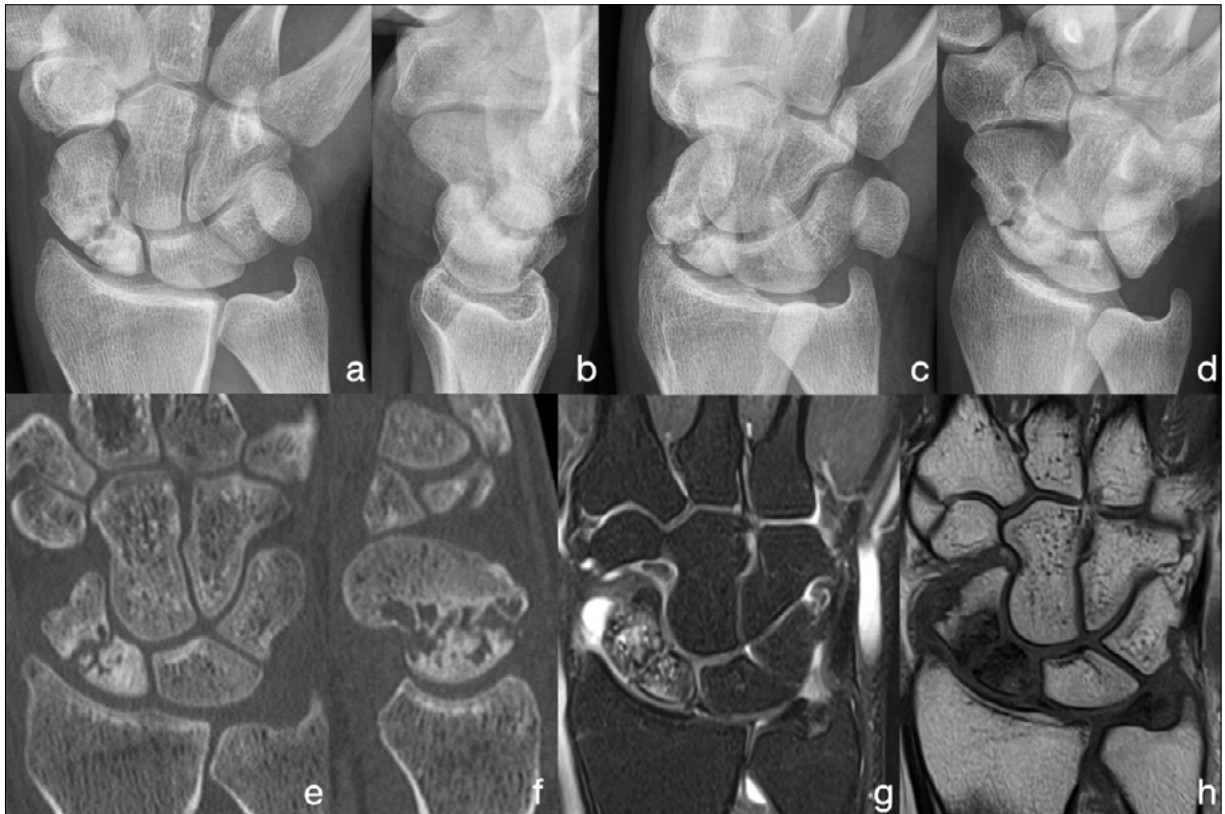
Pre-OP imaging of the scaphoid: a-d radiographs; e,f CT images; g,h MRI images
